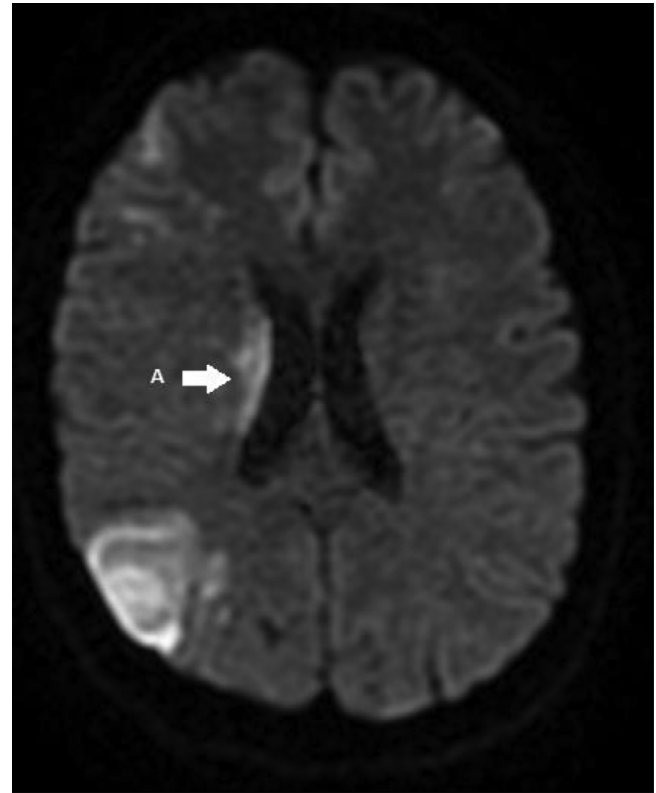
MRI of the head, cross section, Diffusion sequence, fronto parietal and right caudate nucleus hypersignal. (A) Caudate nucleus hypersignal.
